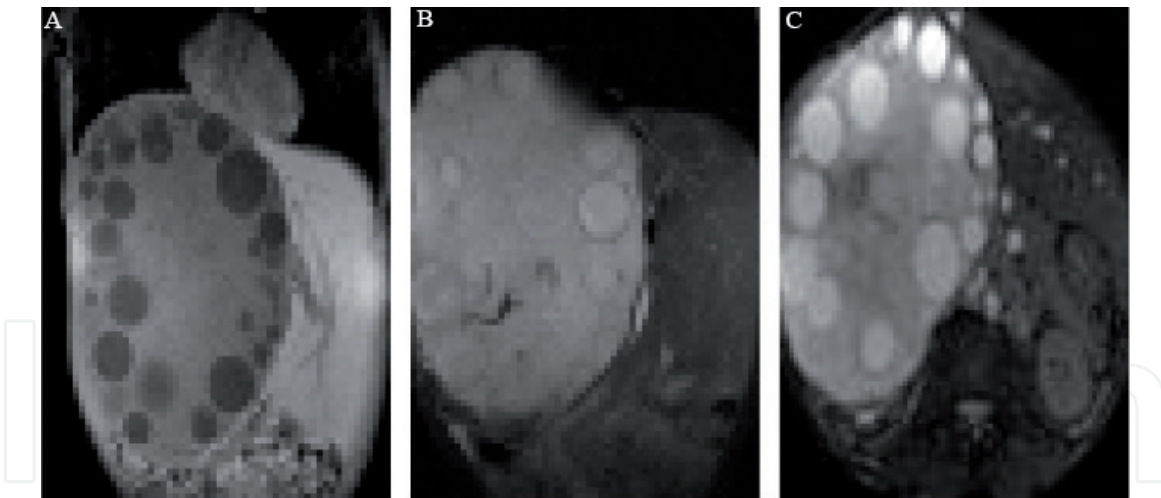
MRI showing hydatid cyst in the liver of a 45 years old male: (A) coronal T1 weighted image, (B) coronal T2 weighted scan and (C) axial T2 weighted scan.
